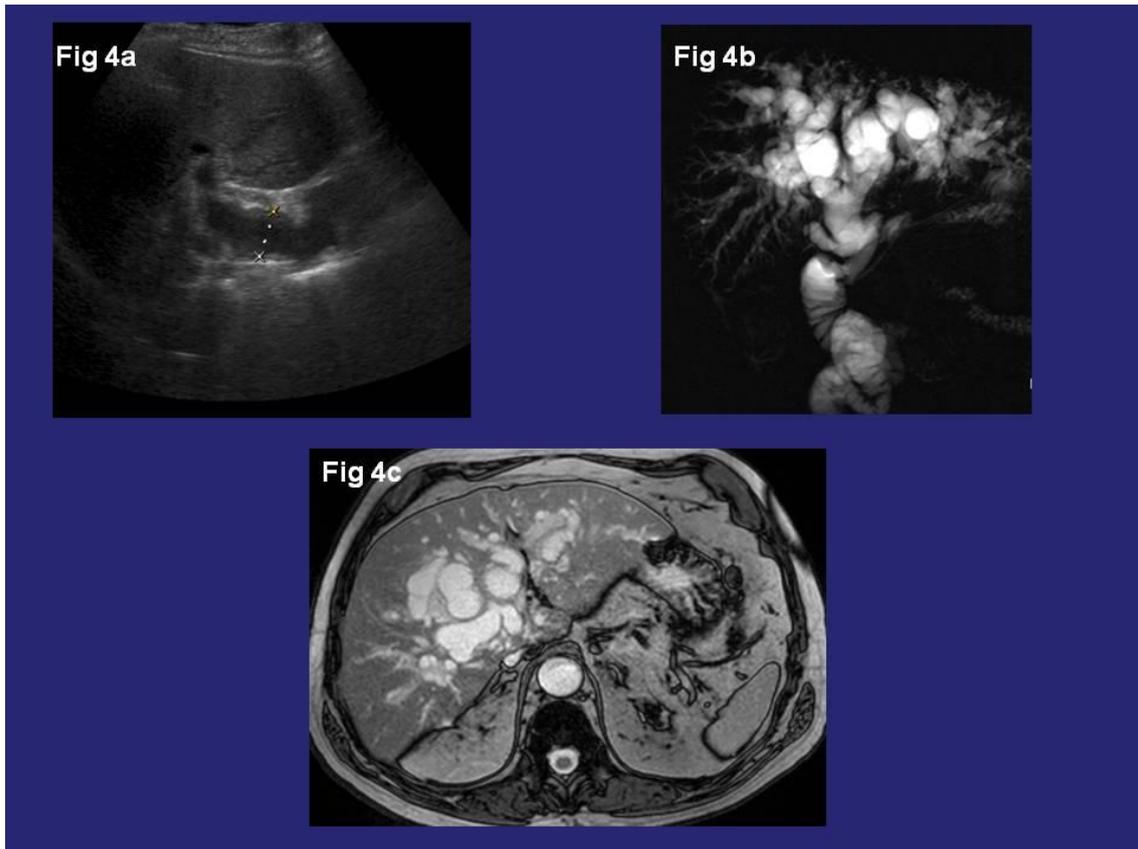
78 years old man with diagnosis of IPMN-B. US shows a dilated common bile duct (figure 4a). MR cholangiopancreatography (figure 4b) shows a massively dilated bile duct without evidence of obstructing lesion. T2-weighted MR image (figure 4c) shows the same findings as in a and b.
